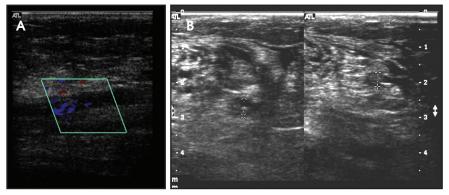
A 75-year-old man with chronic lymphocytic leukemia and acute left upper extremity swelling. (A) Sagittal color Doppler image shows thrombosis of most of the left basilic vein, although there is a small amount of flow. (B) Transverse gray scale images without (left) and with (right) compression demonstrate incomplete compressibility of the left basilic vein (calipers).
